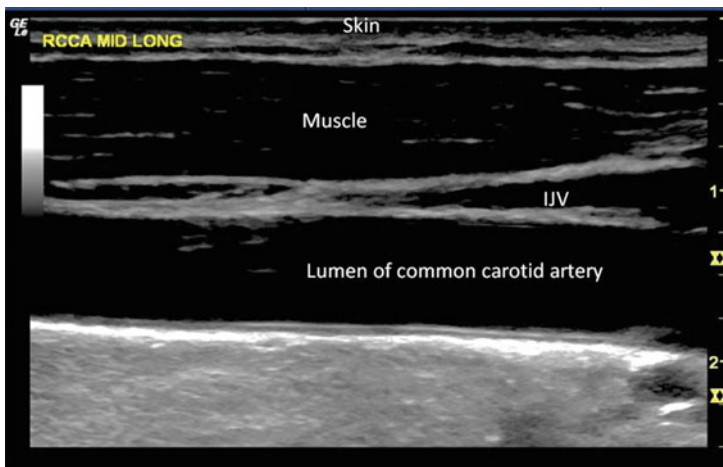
This figure shows the B-mode long axis view of the right common carotid artery. The RIJV is barely visible just above the common carotid artery (see color Doppler image below)
